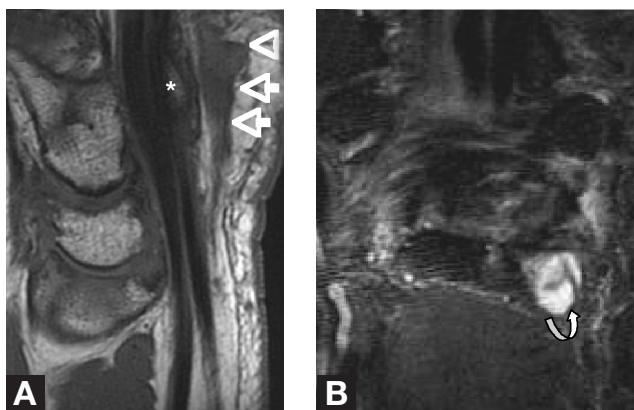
Sagittal proton density (A) and coronal STIR (B) MRI images demonstrate aneurysmal “corkscrew” dilatation of the ulnar artery (straight arrows) just distal to the hook of the hamate (asterisk). On fluid sensitive sequences (B), the aneurysm may be mistake for a complex ganglion cyst (curved arrow).
